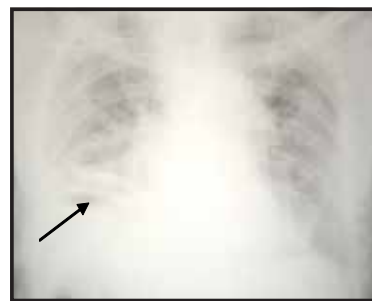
Chest x-ray PA view, showing an air-fluid level in right intrathoracic cavity (marked with an arrow) prior to ICD insertion
